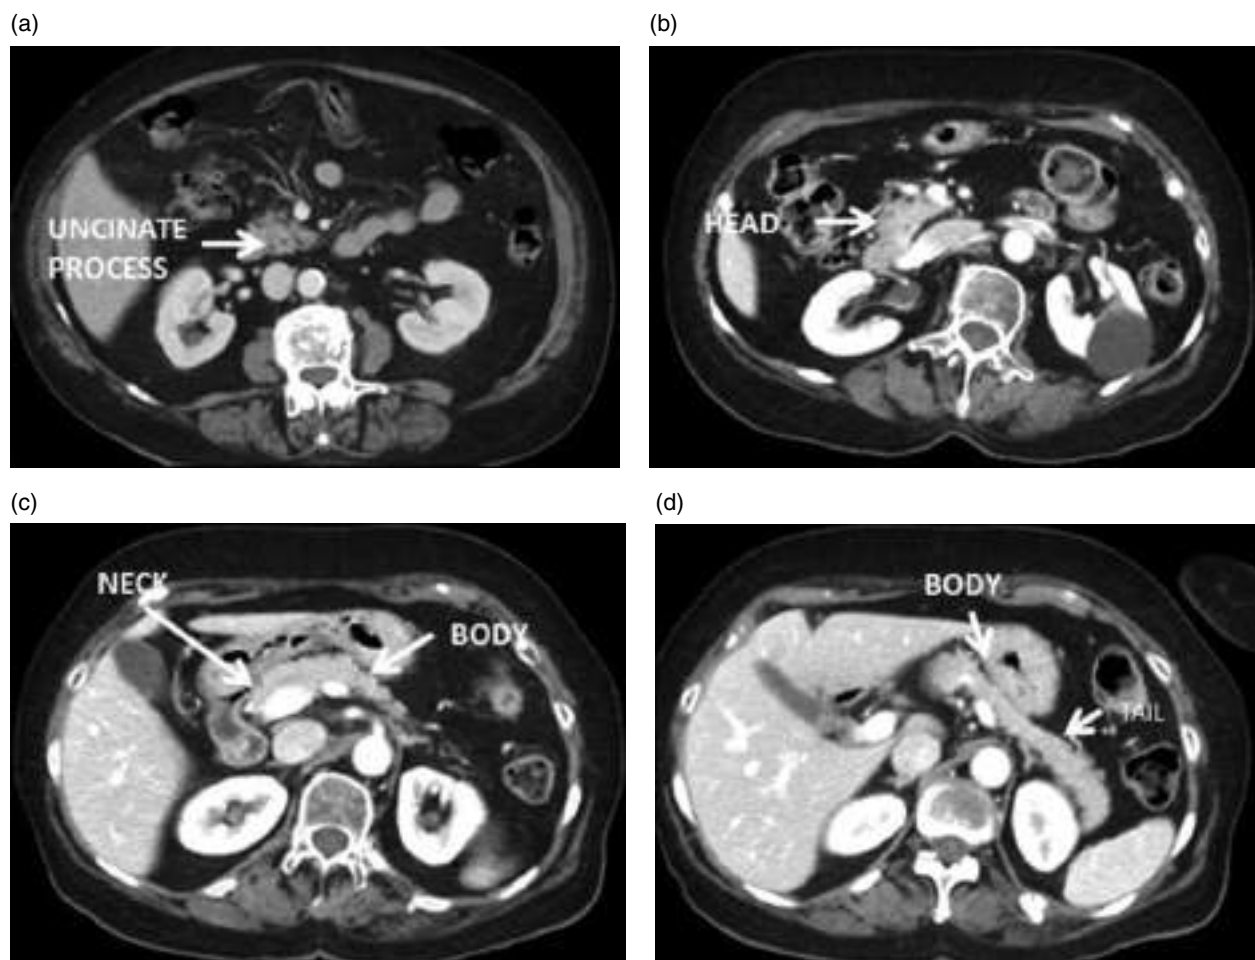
Pancreas. (a-d) Axial contrast-enhanced CT image (pancreatic phase).
